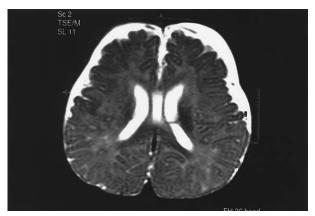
Axial T2-weighted image (TR: 4530, TE: 110 ms) shows bilateral areas of high intensity in the parieto-occipital regions.
